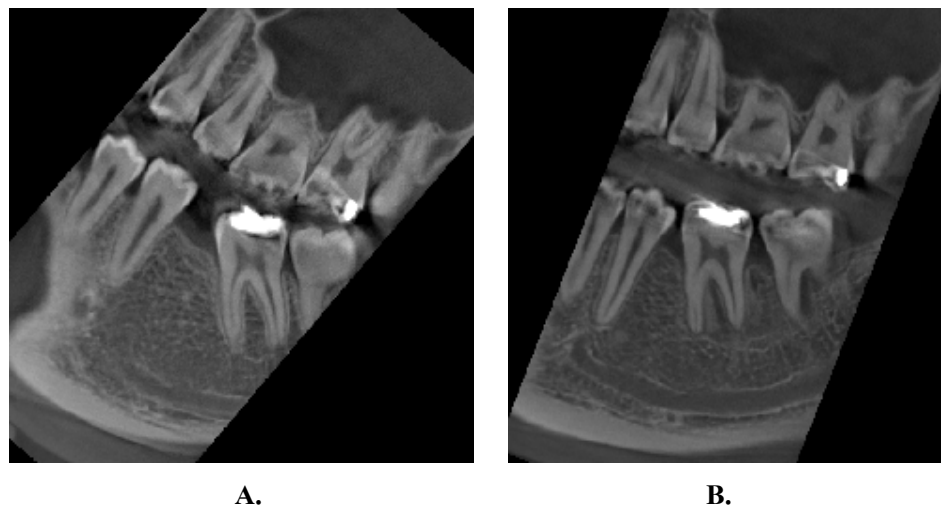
CBCT (axial section) was used to compare the height of crestal bone between before decortications (A) and 3 months after extraction space closed (B).
